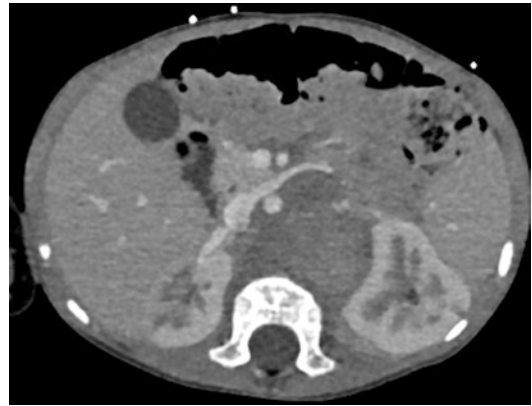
This 22-month-old boy was admitted for arterial hypertension. On ultrasound, an adrenal mass was found (not shown). CE-CT shows a solid hypoenhancing left adrenal mass. It crosses the midline and stretches the right renal vessels causing impaired enhancement of the right kidney
